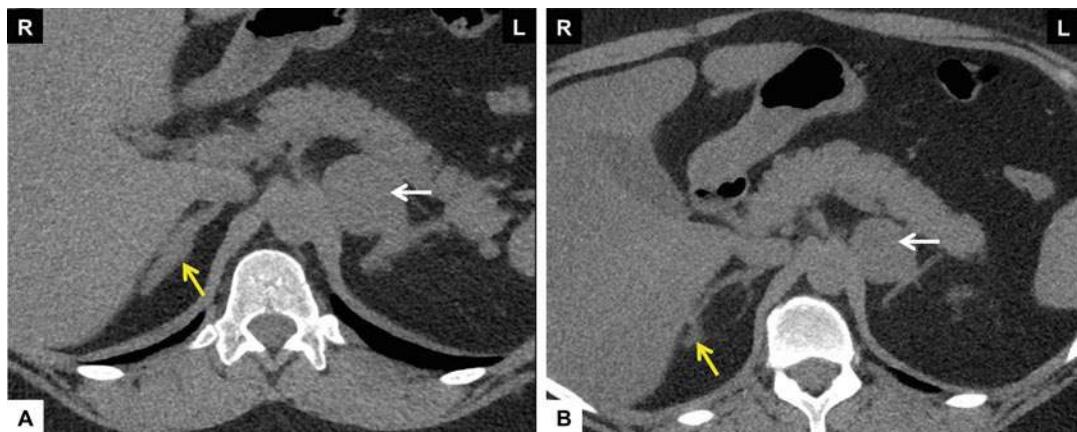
Adrenal computerized tomography (CT) scan images of a 38-year-old female with classic salt-wasting congenital adrenal hyperplasia with a long-standing history of hyperandrogenism. (a) Diffuse bilateral adrenal gland hypertrophy and nodularity are seen (yellow arrow), with a dominant $4.2 \times 3.4 \times 4.1$ cm mass arising from the midportion of left adrenal gland (white arrow). There is no evidence of macroscopic fat within this lesion to suggest a myelolipoma. Precontrast CT density is 29
